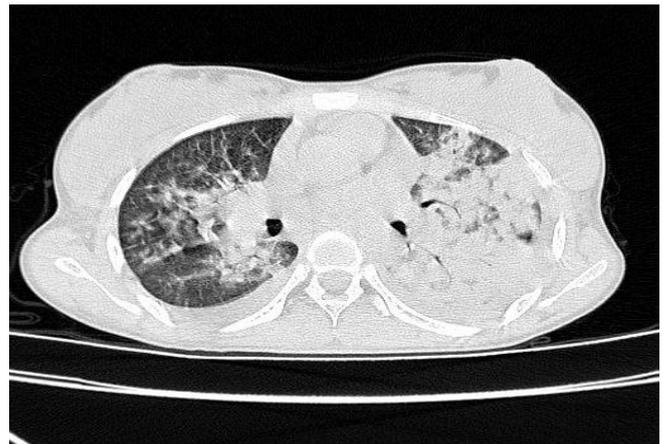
CT THORAX showing interlobular septal thickening and ground glass opacity.
